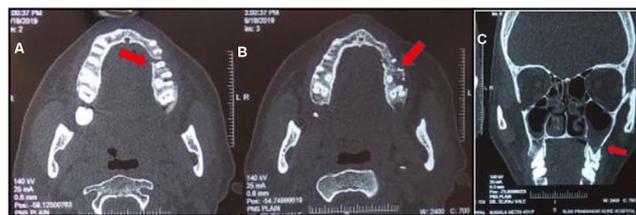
Axial sections of plain computed tomography (CT) – the paranasal sinus (PNS) view showing the destruction of bone involving both the lingual and buccal cortical plates (A, B), and a coronal section depicting extension to the floor of the left maxillary sinus (C)
